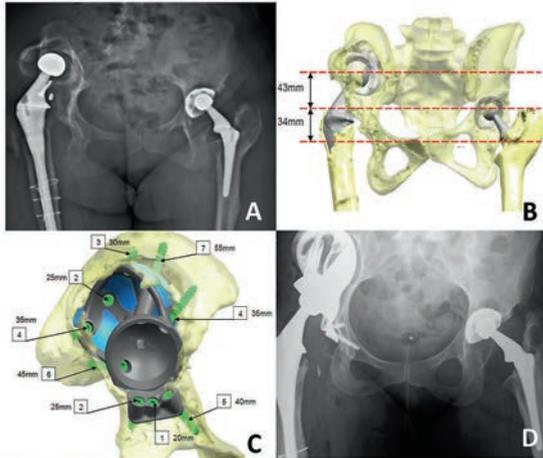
It is inconceivable that a case this complex could be considered and attempted without 3D-CT planning. A) This patient is a 57-year old woman with a large acetabular defect and significant superior migration of the femoral head. B) By reconstructing the pelvis, we are able to determine how much the head needs to be brought down by to restore the correct centre of rotation (43mm). C) A custom acetabular implant can then be designed to repair the defect. The position, number and lengths of screws to be used to fasten the implant to good quality bone is also determined as part of the preoperative plan. D) A post-operative AP pelvic radiograph showed that the plan has been achieved.
